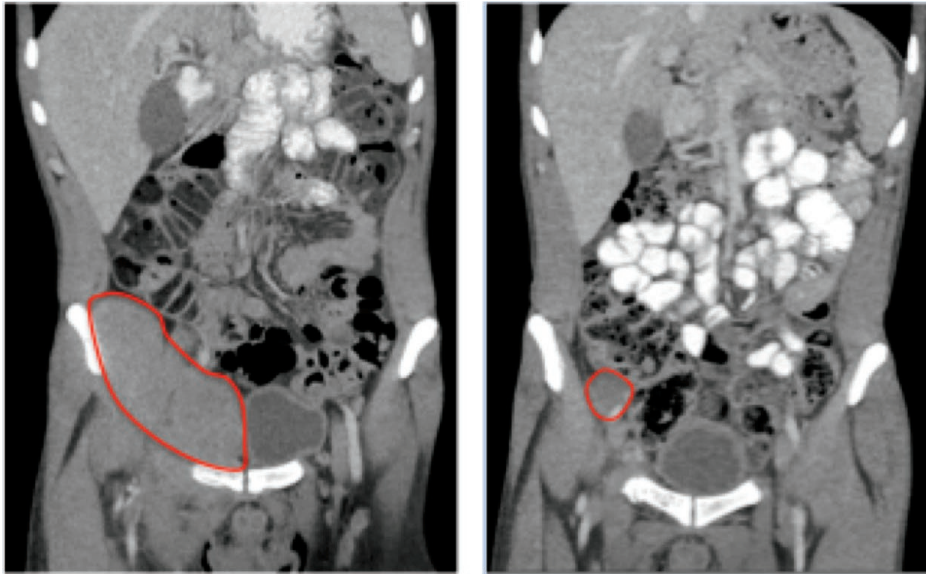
CT images of pelvic disease pre and post chemotherapy
